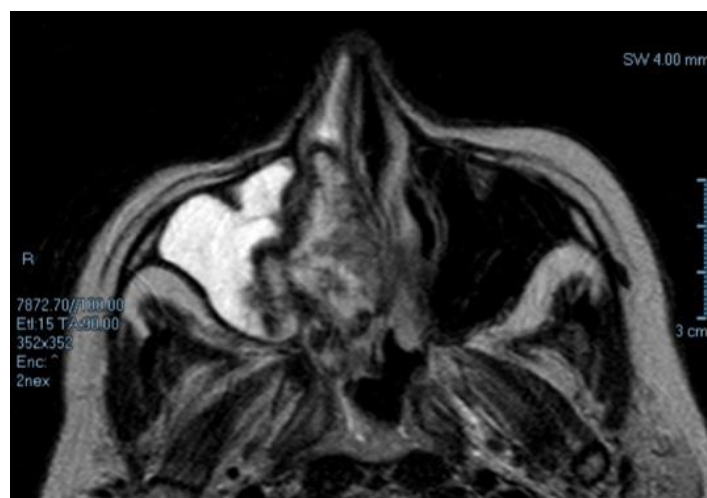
and 7 (MRI revealed a mass at the right nasal cavity extended to the right maxillary antrum keeping with inverted papilloma associated with secondary sinusitis of the right maxillary, right frontal, and right ethmoidal air cells)
